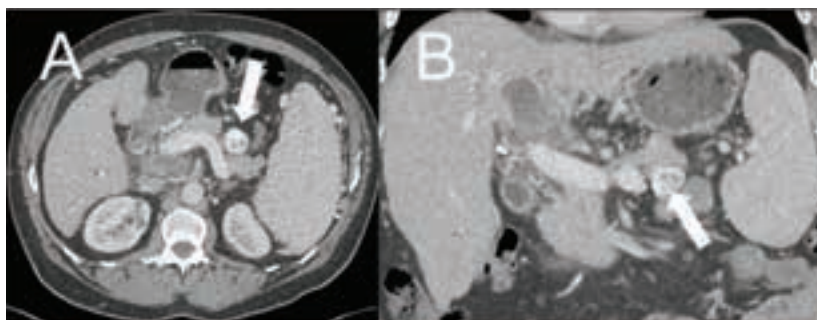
A. Axial and B. sagittal contrast enhanced CT images demonstrating an enhancing mass within the ventral body of the pancreas (white arrow).
